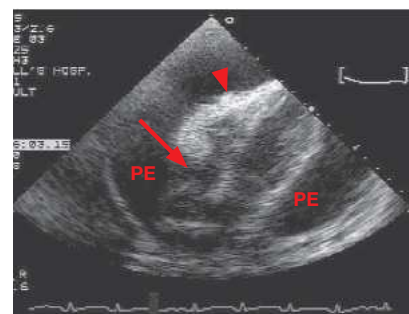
Cardiac tamponade. Echocardiogram in a patient with cardiac tamponade shows a large pericardial effusion with right atrial (arrow) and right ventricular (arrowhead) collapse. (Reproduced with permission from Hall JB et al. *Principles of Critical Care*, 3rd ed. New York, NY: McGraw-Hill; 2005.)
